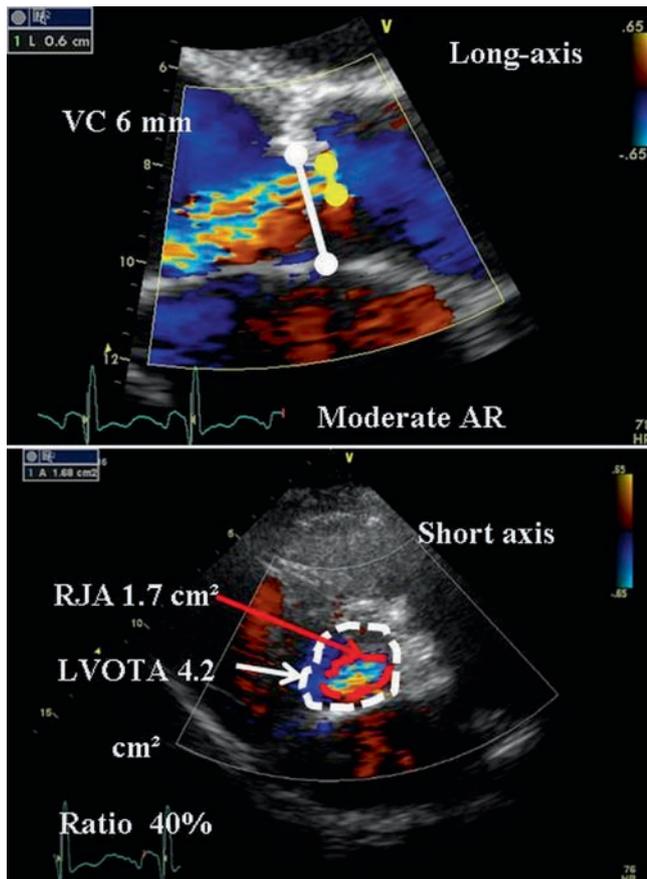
Assessment of AR severity by using colour-flow imaging. *Top* Measurements of the left ventricular outflow dimension and regurgitant jet width (VC = vena contracta) in a patient with moderate AR. *Bottom* Regurgitant jet area (RJA) (red arrow) is measured from the parasternal short-axis view at the aortic valve level. The ratio of RJA to the left ventricular outflow area (LVOTA) (white arrow) can be calculated
